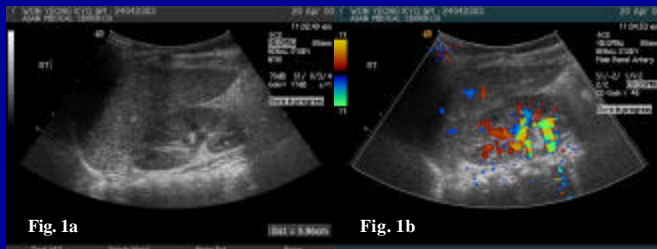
False-positive study for obstruction, which is suspected of having mild hydronephrosis. Fig 1a. The renal pelvis and calyceal system demonstrate minimal separation of the central sinus echo complex by tubular anechoic structure. Fig 1b. Color Doppler ultrasound demonstrate color flow in the tubular structures.
